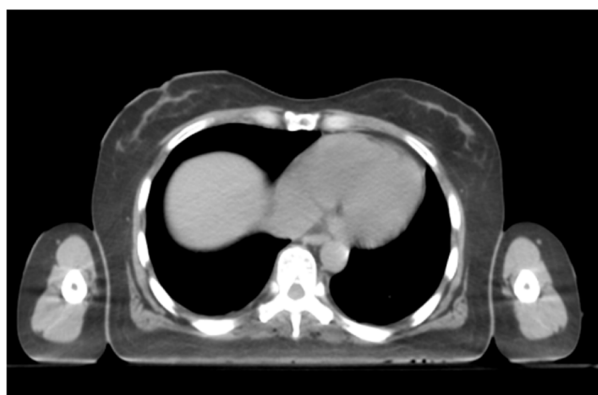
At 10 months of follow-up after radiotherapy, chest CT indicated no pericardial effusion (September 2021).
